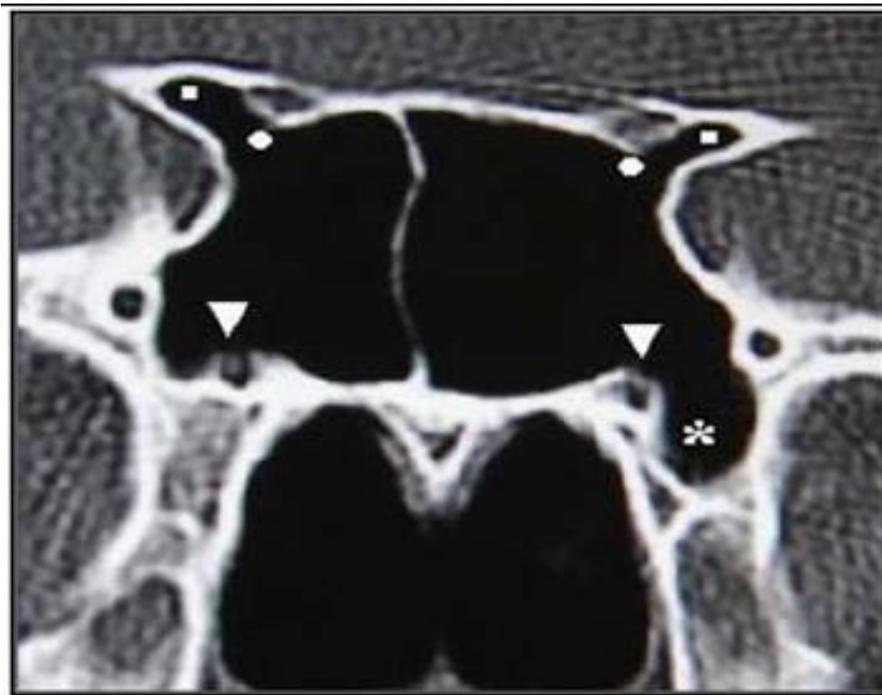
Coronal CT image showing pneumatization of anterior clinoid processes (squares), protrusion and dehiscence of optic nerves (circles), protrusion and dehiscence of vidian nerves (arrowheads), and pneumatization of left pterygoid process (asterisk)
